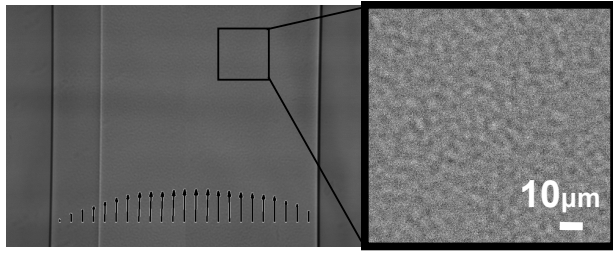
Typical raw X-ray phase contrast image of flowing blood contained with cylindrical vessel. Magnified inset demonstrates the characteristic speckled interference pattern constituting the signal used for PIV. A standard velocimetric profile, showing minimum flow velocities at the wall and maximum in the center, is shown.
